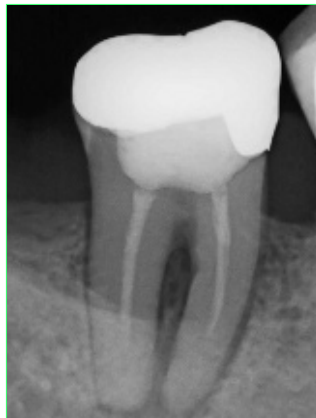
Corresponding radiograph.
